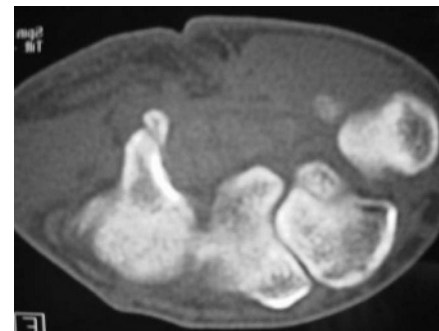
CT scan of left wrist.
